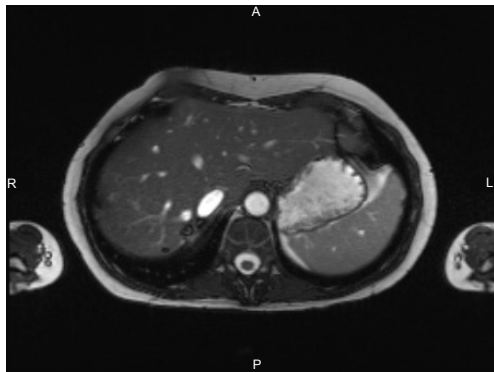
Postoperative MRI T2, IVC of normal caliber above the site of tumour resection.
